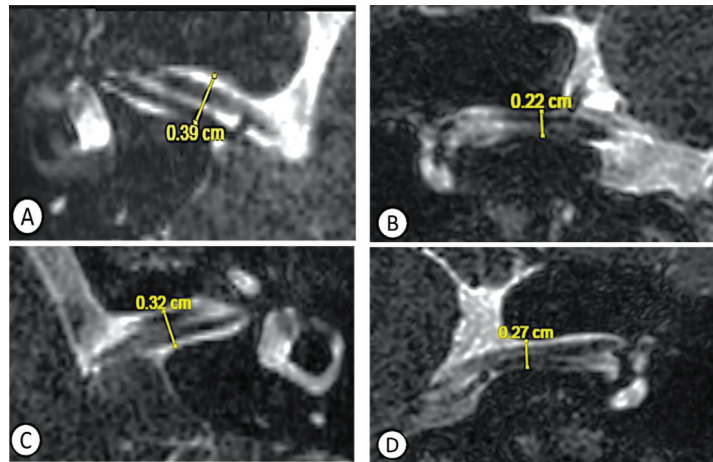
MRI of the inner ear (IAC sections) suggesting a bilateral narrowing of the IAC in the coronal plane, more pronounced on the right side: (A) right ear, axial plane; (B) right ear, coronal plane; (C) left ear, axial plane; and (D) left ear, coronal plane.
